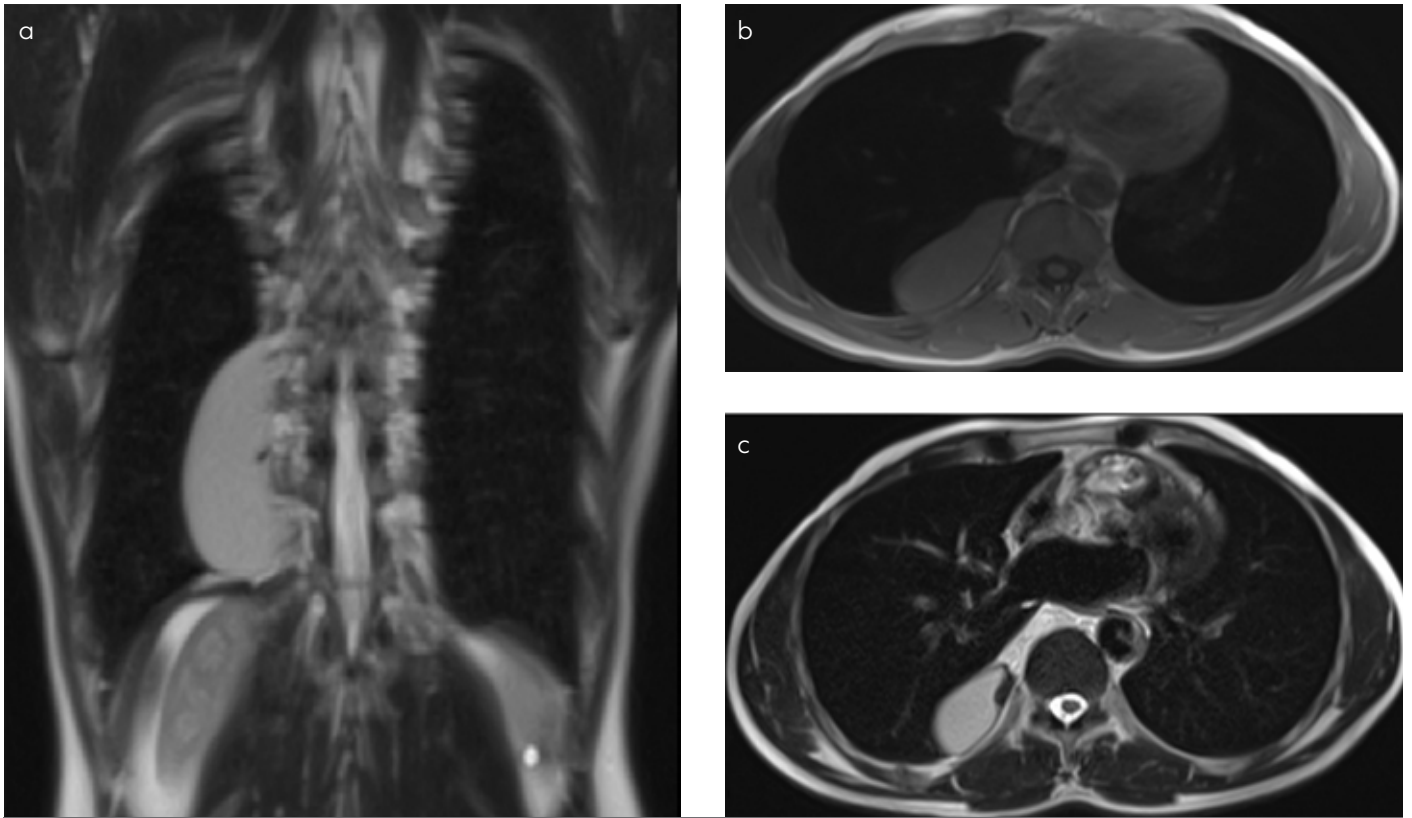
a-c. Coronal (a) and axial (b, c) magnetic resonance images of the chest demonstrated a unilocular cystic tumour with a sharply defined contour located in the right posterior mediastinum
